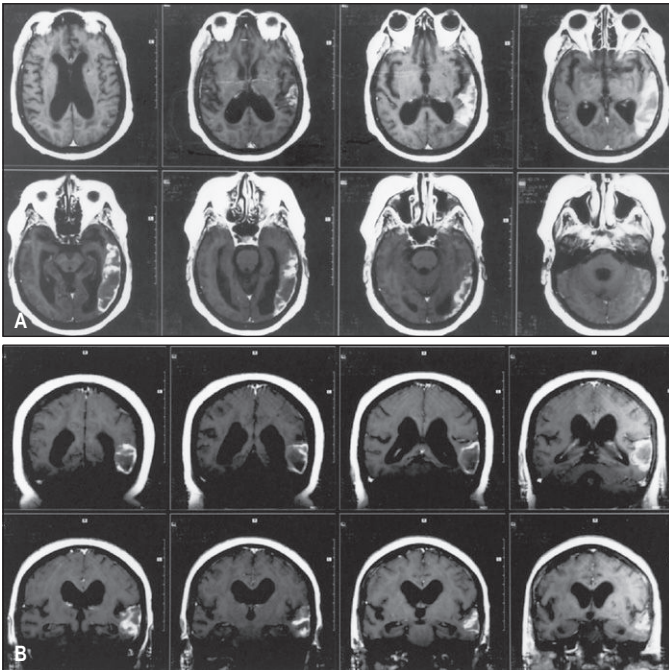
MRI of a patient with Wernicke's aphasia caused by a temporal lobe lesion
